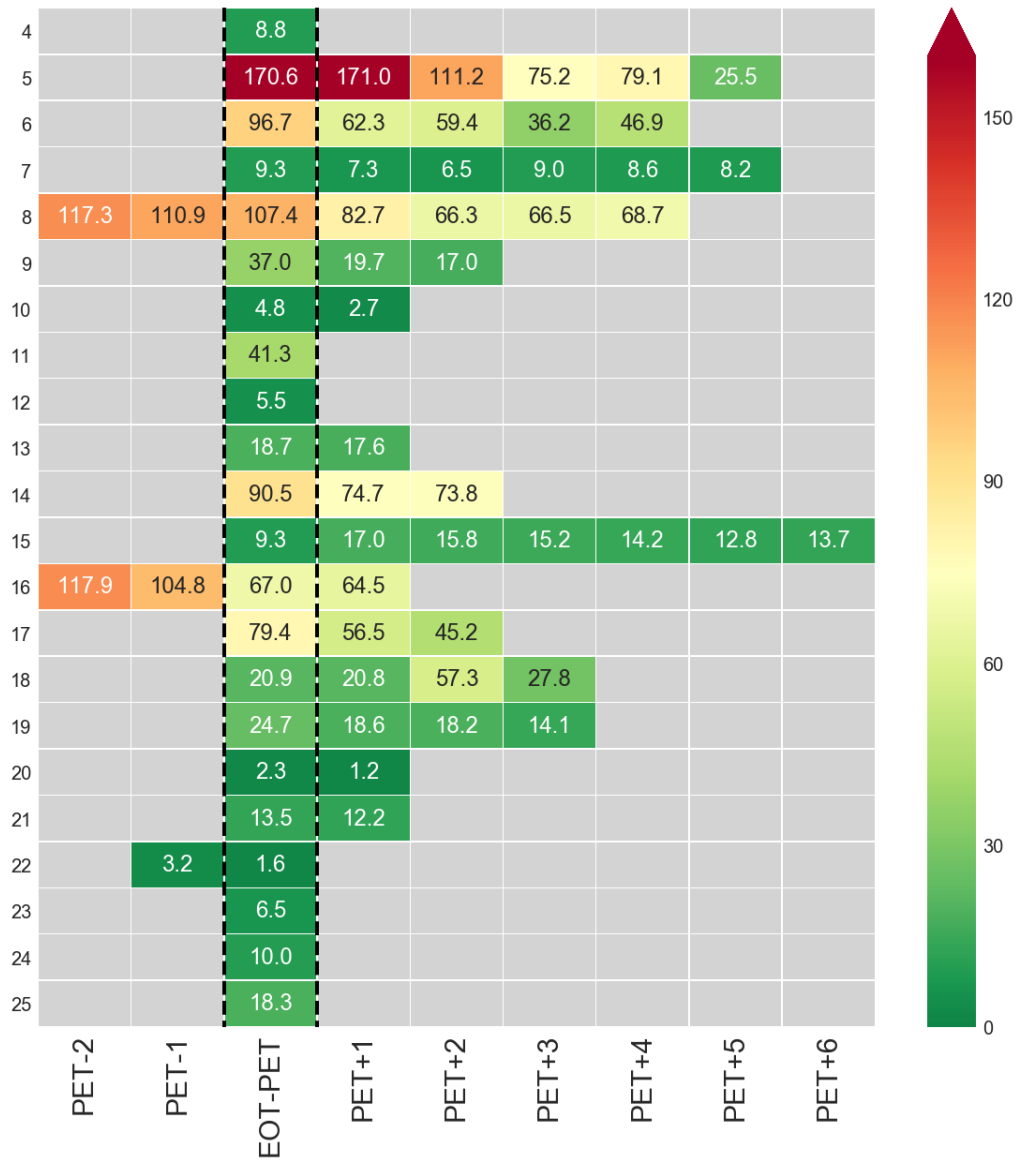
Metabolic tumor volume in negative EOT FDG-PET non-progressing NCI patients.
